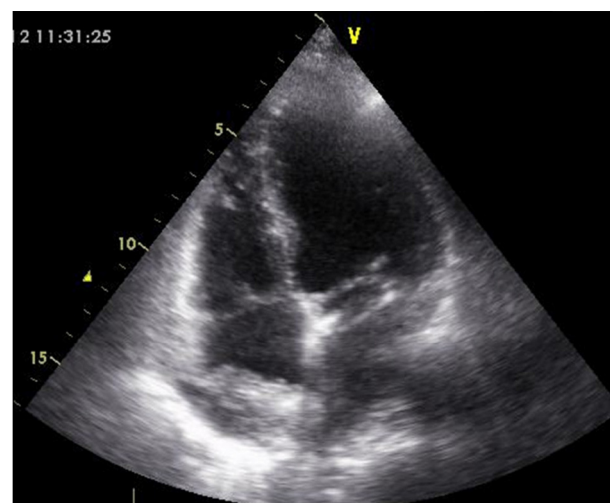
Initial assessment by transthoracic echocardiography (apical 4-chamber view), showing a heterogeneous echodense image (3 cm × 2.2 cm) adhering to the right atrial roof, interpreted as a thrombus.
